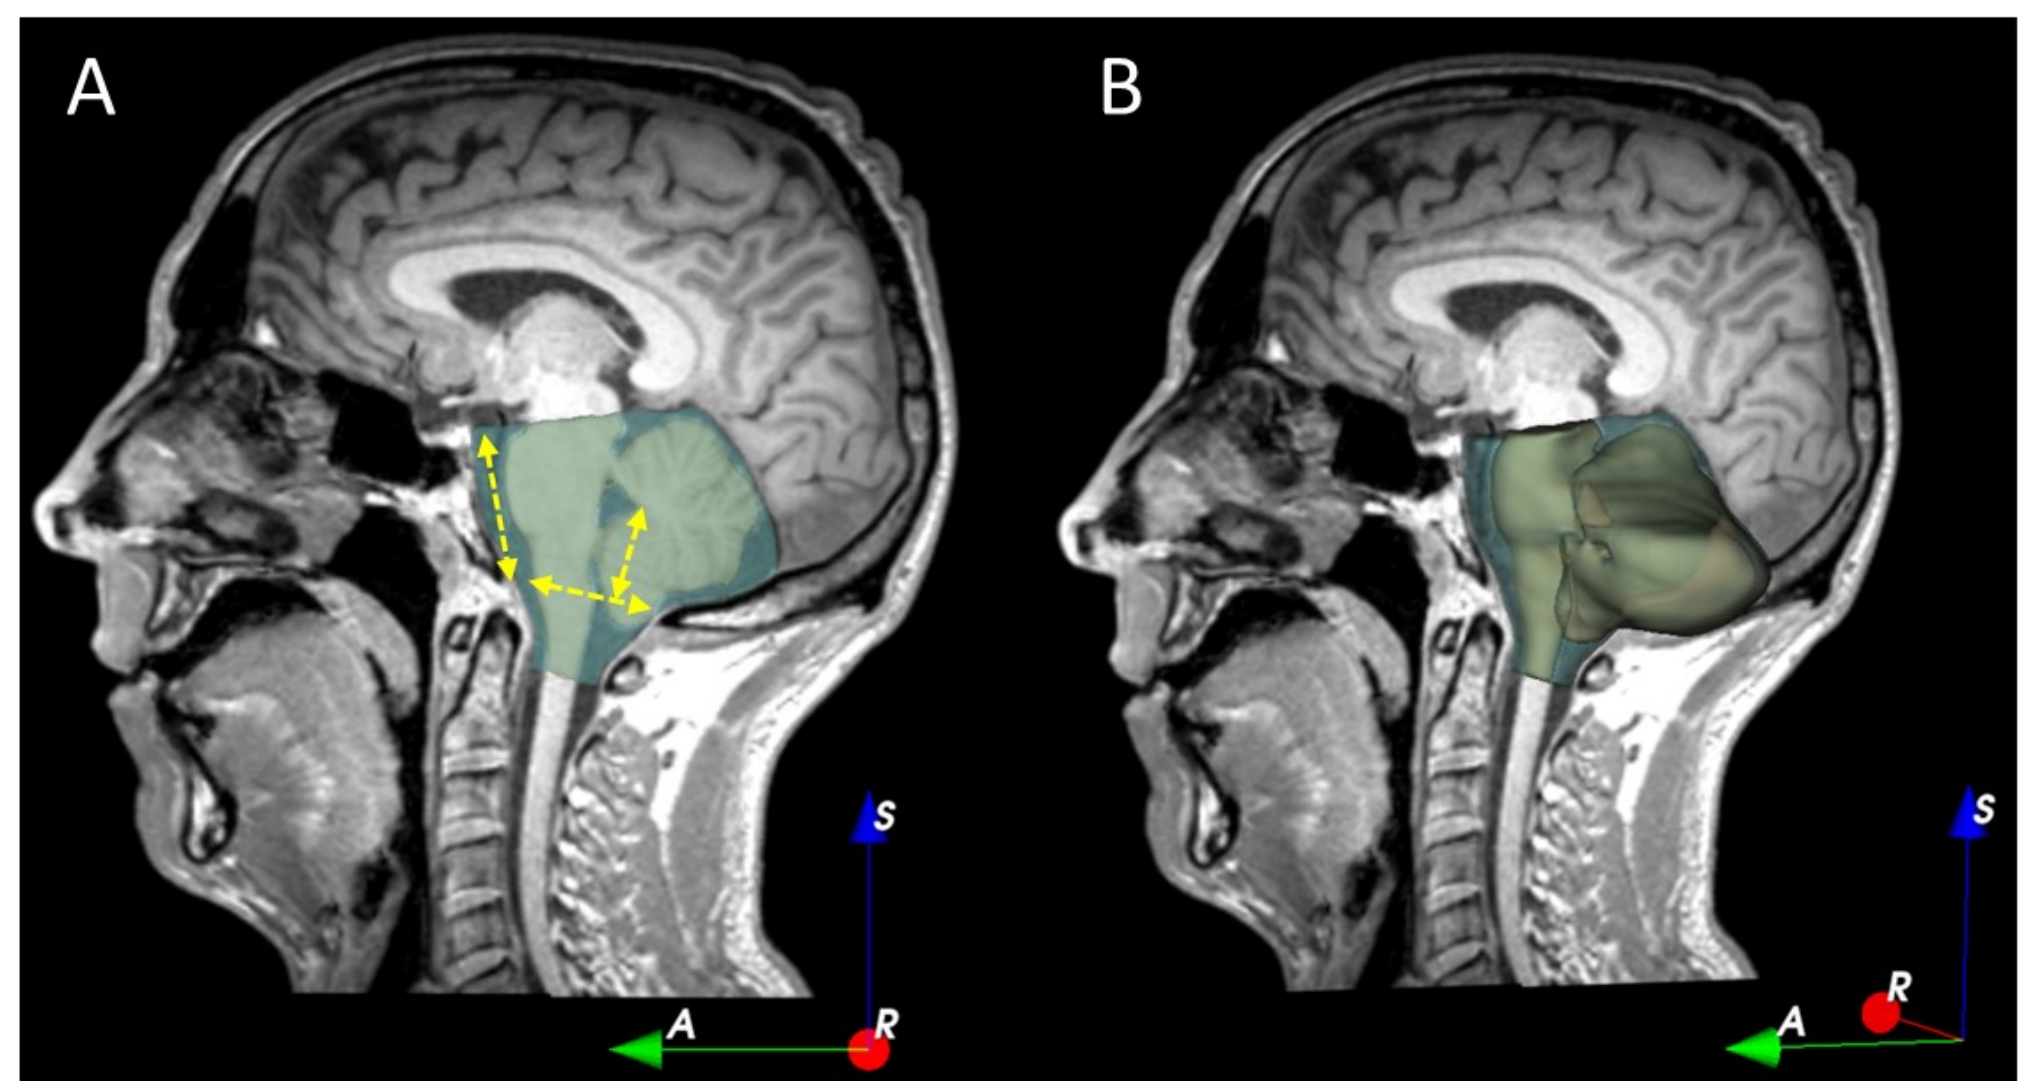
MRI of a patient with Chiari malformation, highlighting the volumes of the hindbrain (brown) and CSF space (blue). A) Shows the areas covered on the mid-slice, with examples of common 2D measurements. B) A 3D view of the CSF and hindbrain volumes for reference.
